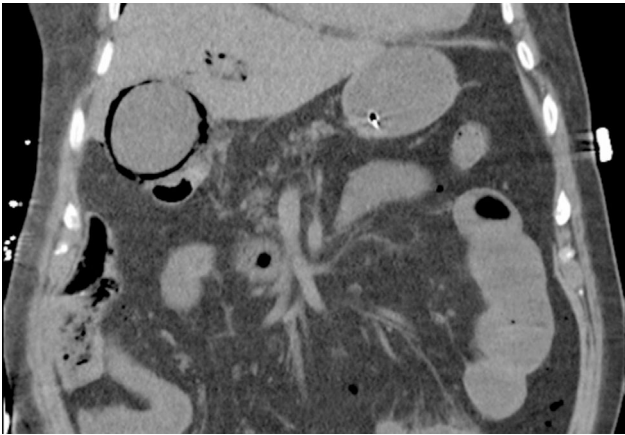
Coronal Abdominal Computed Tomography presented gas in the wall and lumen of the gallbladder and air in the intrahepatic biliary tract.
